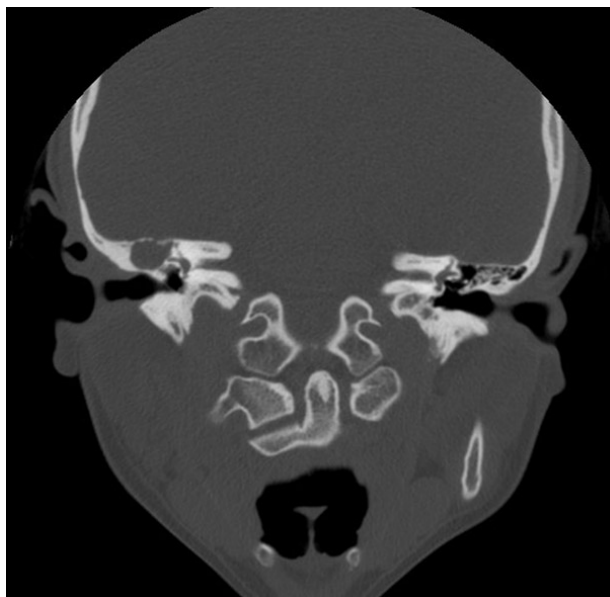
Axial view (a.) and coronal view (b.) of computed tomography scan of the temporal bone showing a mastoid soft tissue density mass with epitympanic extension and ossicular involvement.
